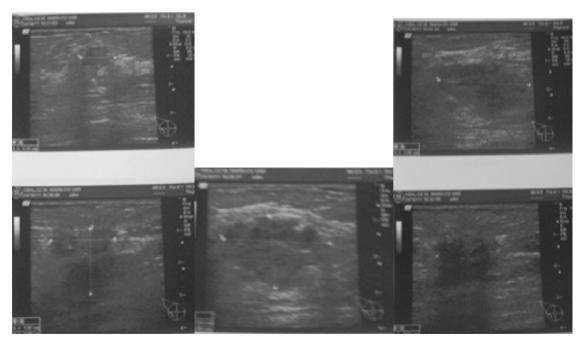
Diagnostic sonography of the right breast.
